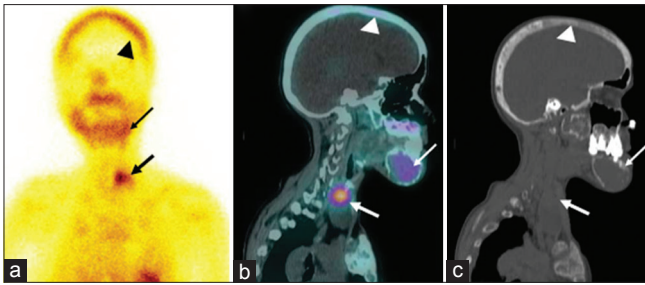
^{99m}Tc-sestamibi imaging, (a) planar delayed anterior image, (b) sagittal-fused single photon emission computed tomography/computed tomography, and (c) computed tomography images showing focally increased tracer uptake in a soft-tissue lesion at the superior aspect of the left lobe of the thyroid gland (thick arrow), cortical lytic lesions in skull (arrowhead), and mandible (thin arrow)
